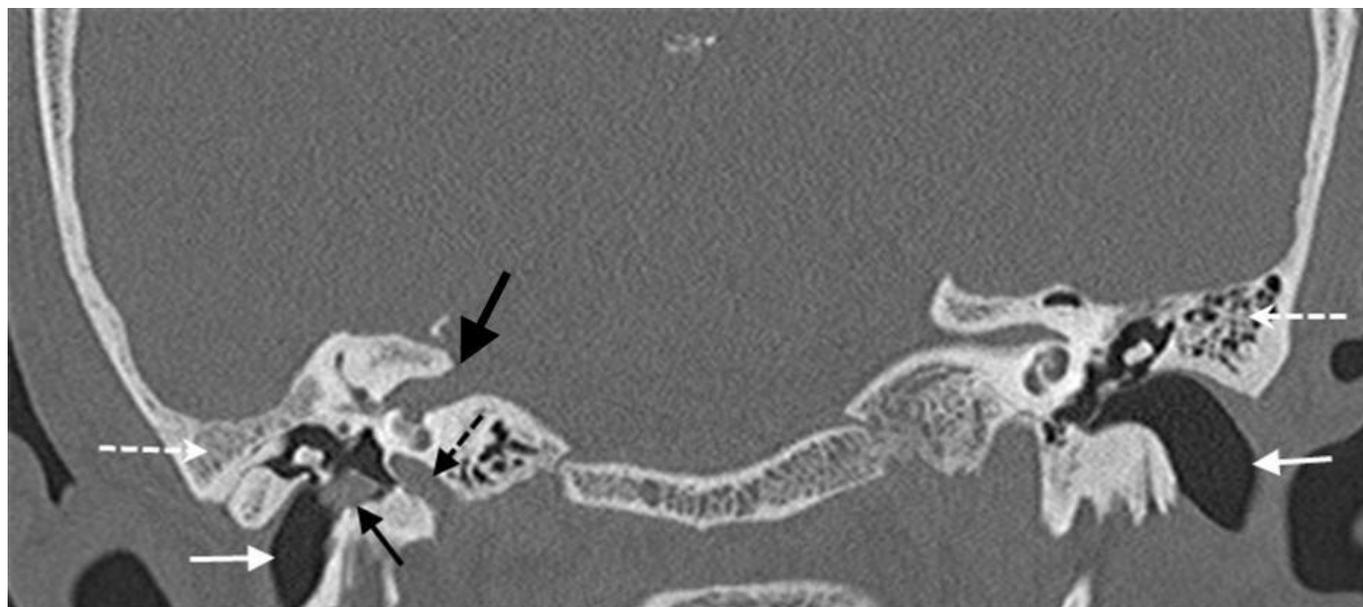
Coronal computed tomography (native, 120kv/120mAs) image in a 46 year-old man allows a good overview of the pathologic findings in hemifacial microsomia: Complete absence of pneumatization and hypoplastic appearances of the right mastoid bone (white dotted arrows). Right external auditory canal shows reduced diameter (white arrows) and inside a soft tissue mass in front of the right tympanic membrane (black arrow). Note the narrowing of the right internal carotid artery canal (black dotted arrow). Additional shortening of the right internal auditory canal (black spaced out arrow).
